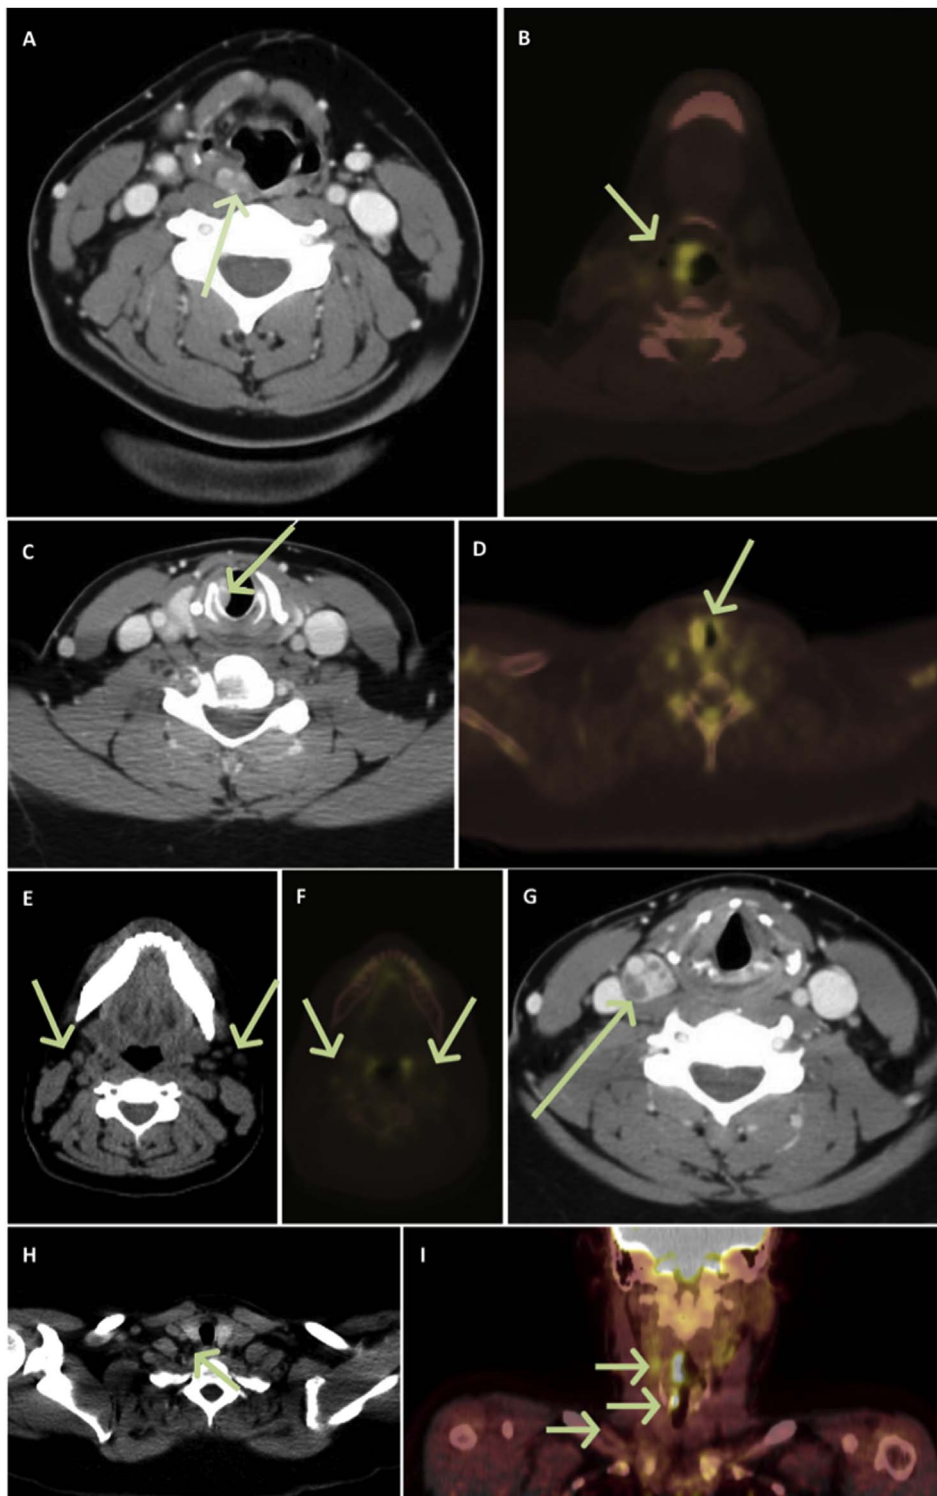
Diagnostic imaging. A: Axial neck CT with contrast shows asymmetric, heterogeneous rim-enhancing soft tissue mass measuring 1.0 cm × 2.1 cm × 3.3 cm originating from the right aspect of the epiglottis and aryepiglottic folds and protruding into the supraglottic larynx. B: Epiglottic mass demonstrates intense FDG avidity on axial PET overlaid on CT. C: Axial neck CT with contrast shows a mass arising from the infraglottic region of the right laryngeal wall. D: Infraglottic mass demonstrates intense FDG avidity on axial PET overlaid on CT. E: Bilateral subcentimeter enlarged cervical lymph nodes. F: Bilateral node FDG avidity in PET overlaid on CT is concerning for metastatic disease. G: Axial neck CT with contrast shows a heterogeneous mass, likely a level 3 necrotic lymph node, abutting and partially encircling the right common carotid artery. H: Subcentimeter level IV nodes. I: Sagittal image from PET/CT demonstrating asymmetric FDG uptake in right larynx, right vocal cords and bilateral hypermetabolic cervical lymph nodes at levels II, III, IV.
